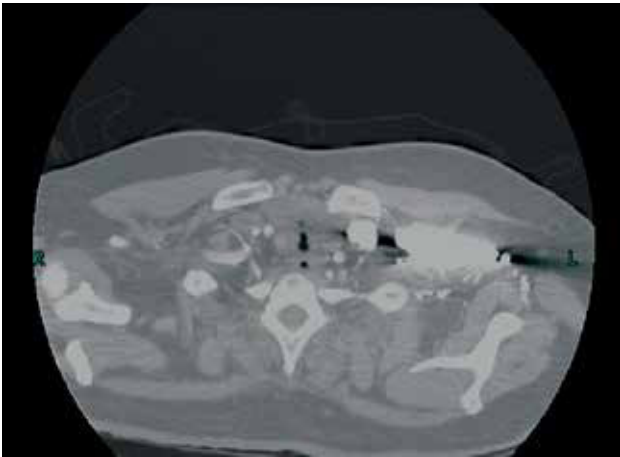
Computed tomography of the patient depicting tracheal stenosis 3 cm below the vocal cords.
